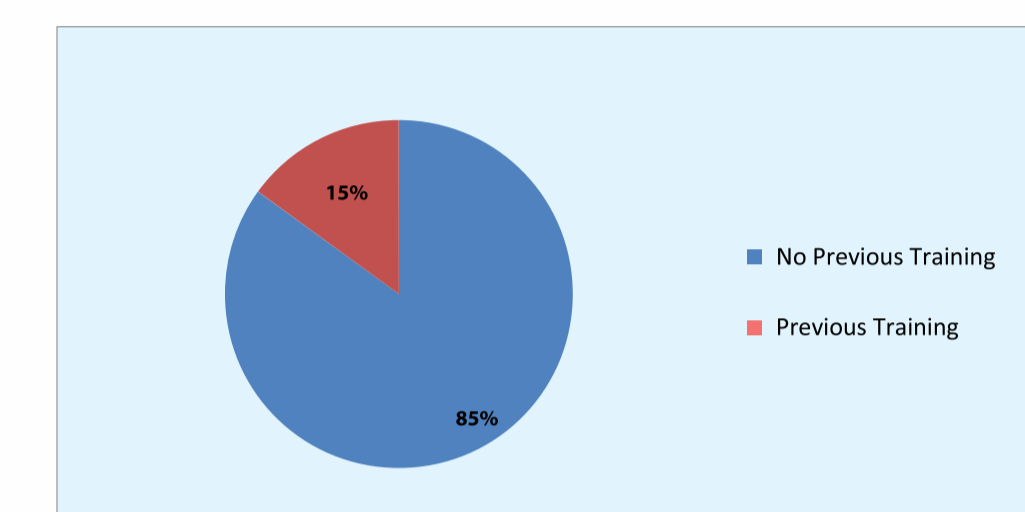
Previous Training on Medical Ultrasound
